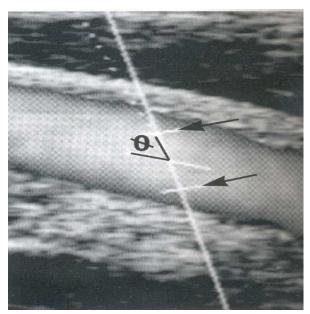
Doppler spectral analysis
